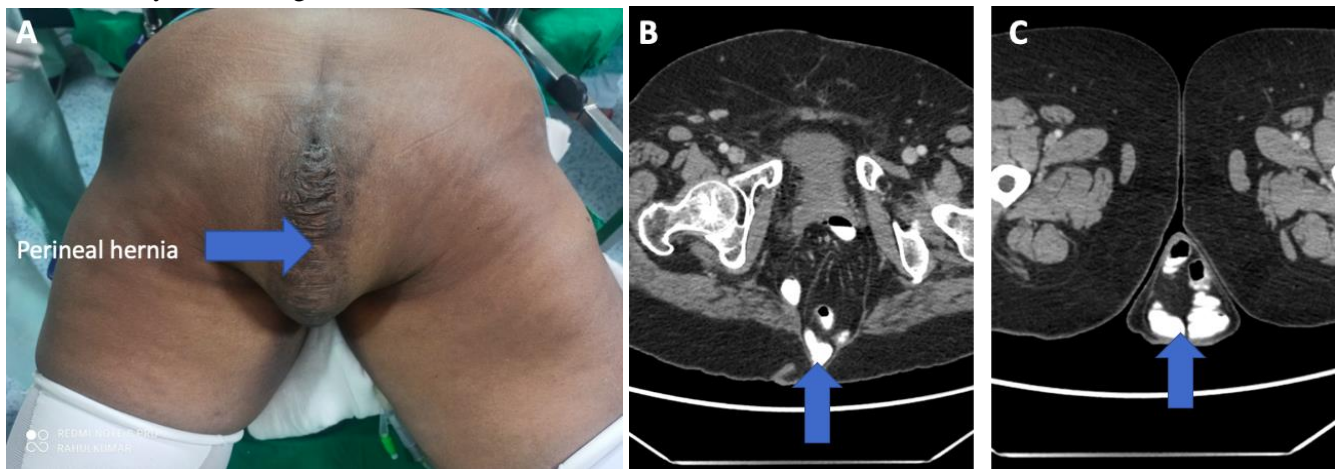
A) large perineal hernia, shown by arrow. B) MRI image showing herniation between gluteal maximus muscles, shown by arrow. C) Hernia sac at the level of upper femur, shown by arrow.
